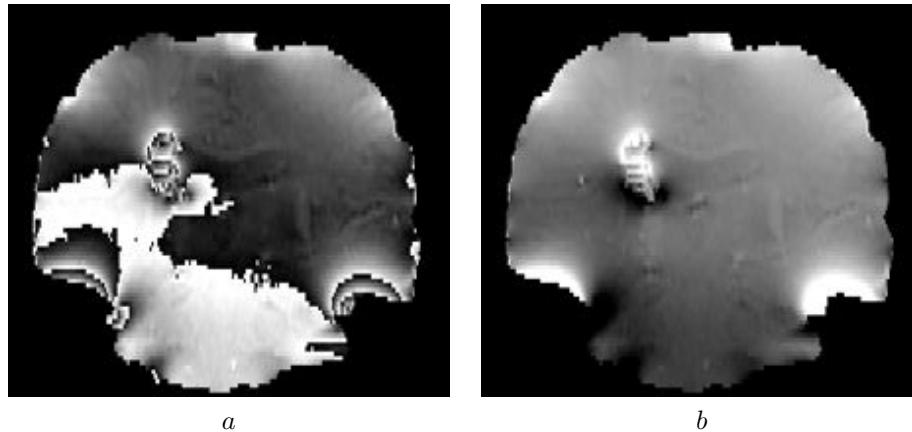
Example phase unwrapping for MR images of the human head. (a) shows the phase image with multiple 2π wraps. (b) is the unwrapped phase image. The unwrapping was performed using the phase unwrapping software presented in chapter 4.
